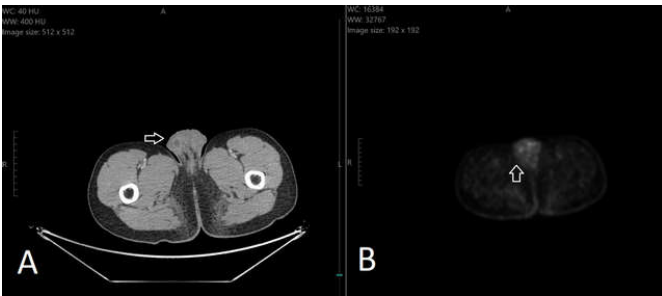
Post operative whole body PET CT showing the post operative inflammatory changes(A) in CT and the associated metabolic uptake (B) in PET
